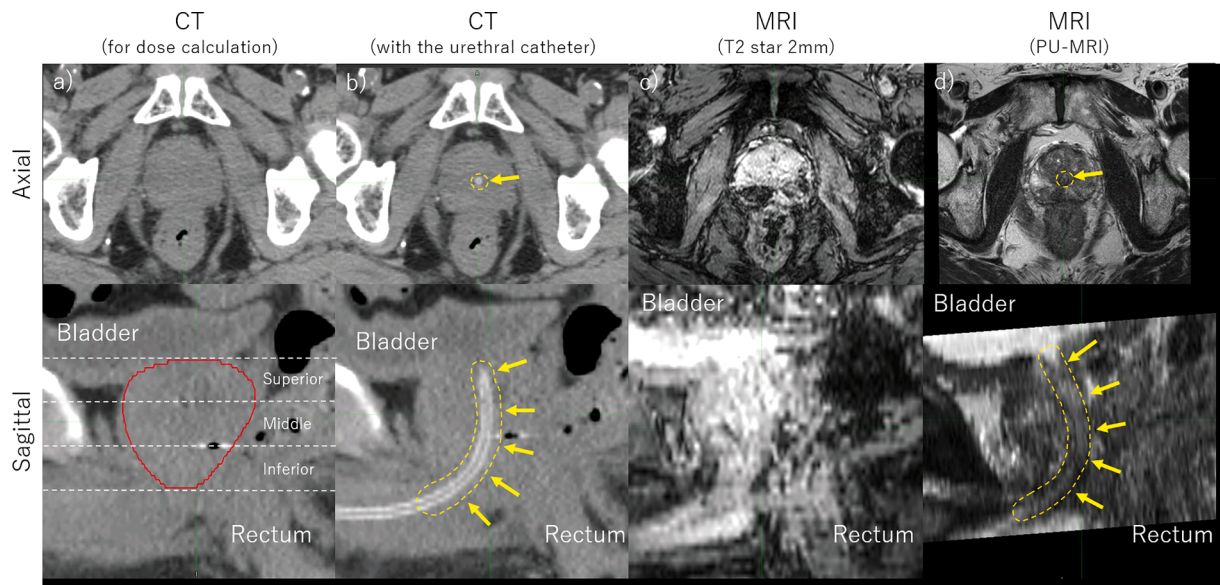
Axial and sagittal images during treatment planning (Case 2). The prostatic urinary tract (yellow arrow) was identified with a urethral catheter in CT and without a urethral catheter in PU-MRI. We divided the prostatic urinary tract into three even segments in the CTV (superior, middle, and inferior). (a) Treatment-planning CT for dose calculation, (b) treatment-planning CT with a urethral catheter for visualizing the prostatic urinary tract, (c) conventional MRI without a urethral catheter for target contouring, and (d) PU-MRI with TSE. CT: computed tomography, PU-MRI: post-urination magnetic resonance imaging, TSE: turbo spin echo, CTV: clinical target volume.
